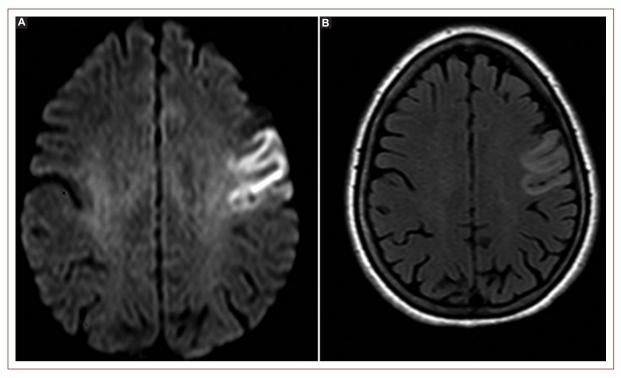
Diffusion-weighted image (A) shows diffusion restriction in the left superior frontal gyrus. Fluid-attenuated inversion recovery magnetic resonance imaging (B) confirms subacute infarction involving the left superior frontal gyrus.
